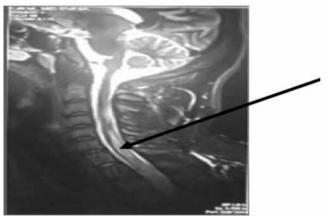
MRI of the brain and spine: hypersignal T2 intramedullary ischemic lesions spreading from C3 to C7 with a swollen dorsal medulla
